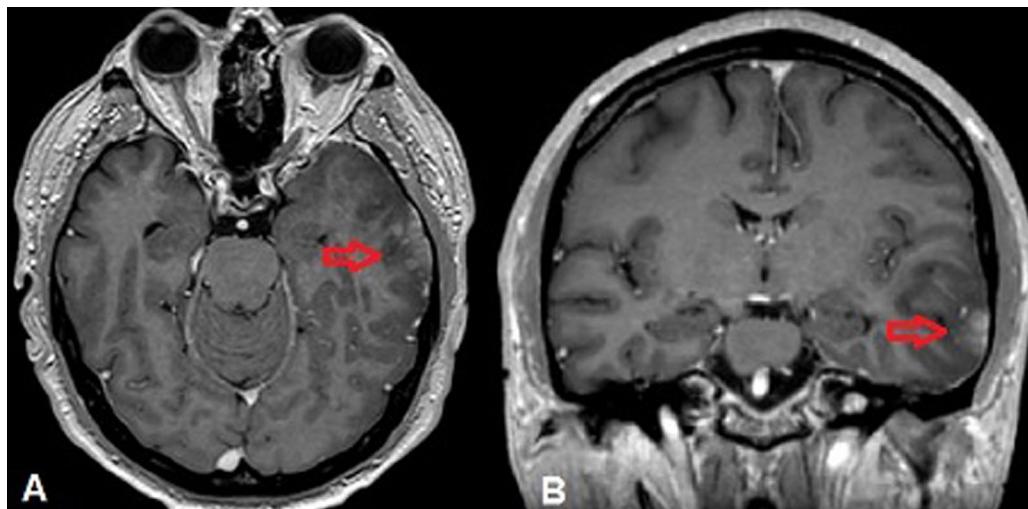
Brain MRI T1 with contrast axial cut (A) and coronal (B) visualizing contrast-capturing left temporal lesion (red arrows)
